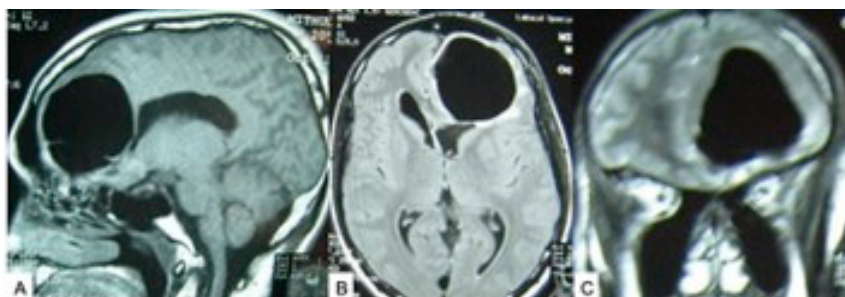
MRI of the brain (A–C) (sagittal, axial, and coronal views, respectively) showing tension pneumocephalus with mass effect that requires surgical decompression (through burr hole). Source: Figure by authors.
